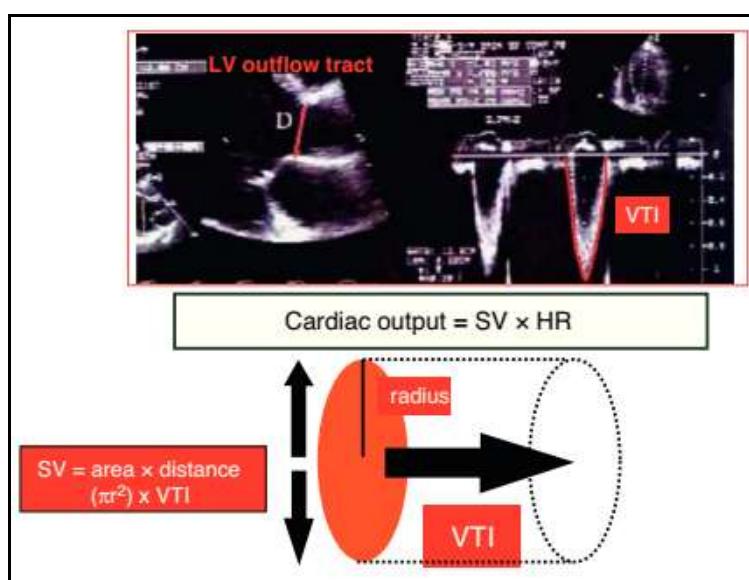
Calculation of cardiac output using echocardiography⁵
